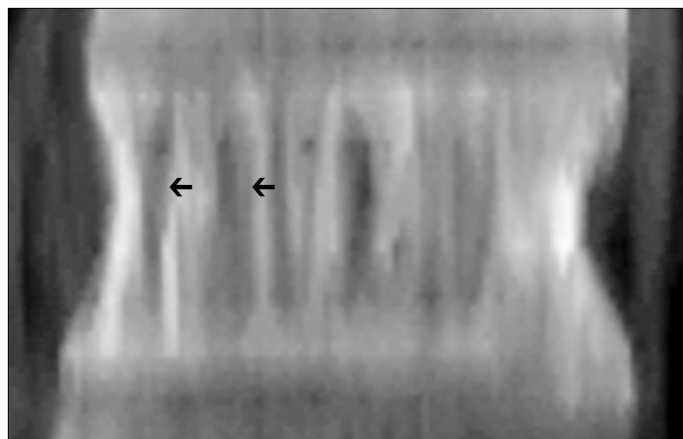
Coronal reformatted CT image of T12 demonstrates vertically oriented radiolucent areas (arrows) adjacent to thickened trabecular struts.
